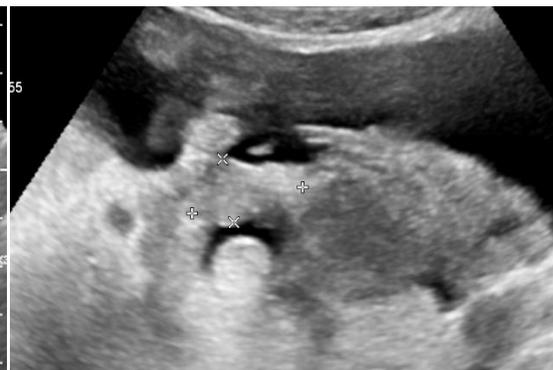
Transabdominal ultrasound shows right and left ovary with no evidence of adnexal mass lesion.
